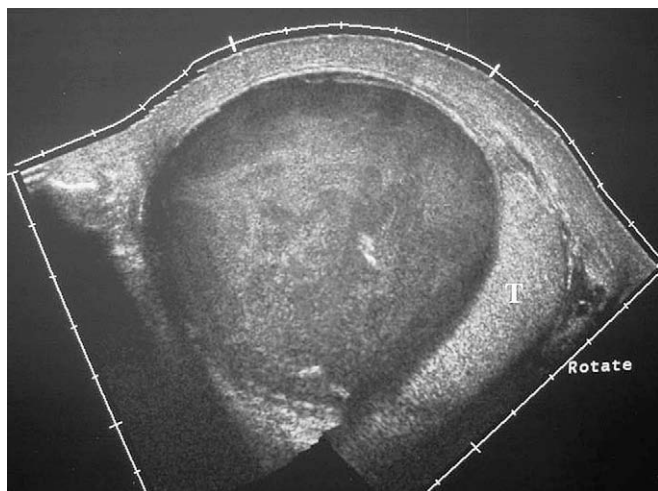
Compression effect on the right testis (T) caused by the right hemiscrotal pyocele is documented successfully by the transverse EFOV sonogram. Oedema within the cutaneous and subcutaneous tissue also is shown.
